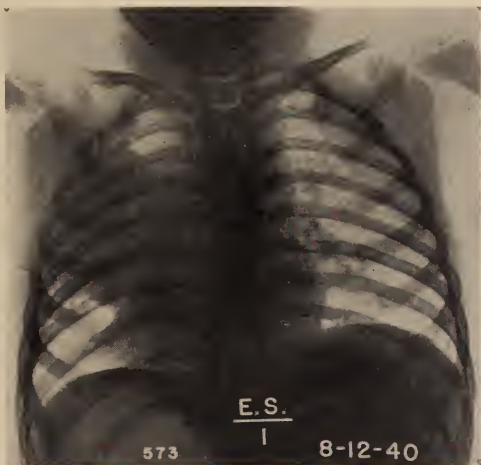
X-ray film showing a large sharply demarcated shadow in the left chest which appears to be situated either in the lung or in the pleura and does not suggest a mediastinal tumor. (In the lateral view the density was hemispherical and was situated anteriorly.)
